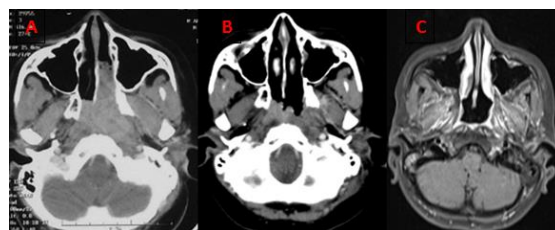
CT scan and MRI of the Nasopharynx with contrast before and after treatment A. CT scan before treatment, B. CT scan after induction chemotherapy, C. Contrast-enhanced T1-weighted MRI of the Nasopharynx for a two-year follow-up after chemoradiation treatment with complete response
